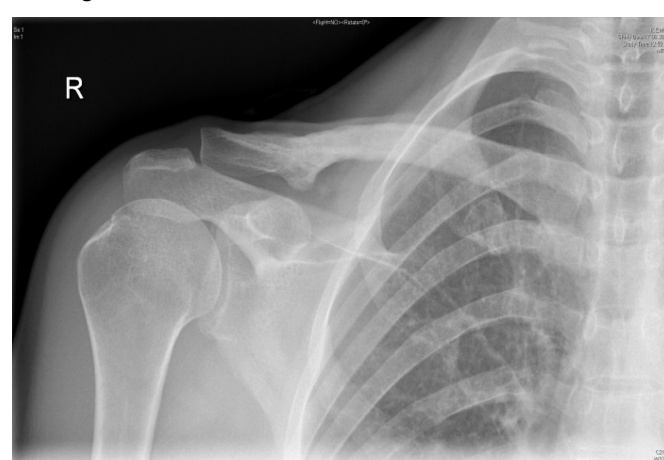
42 year's woman's follow-up shoulder AP x-ray image showing that achieved union clavicle comminuted fracture after the implant is removed
